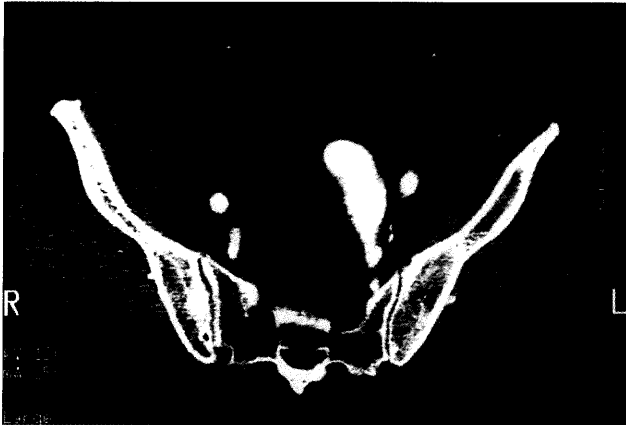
Pelvic CT shows an 8-cm left internal iliac artery aneurysm with thick mural thrombus.
